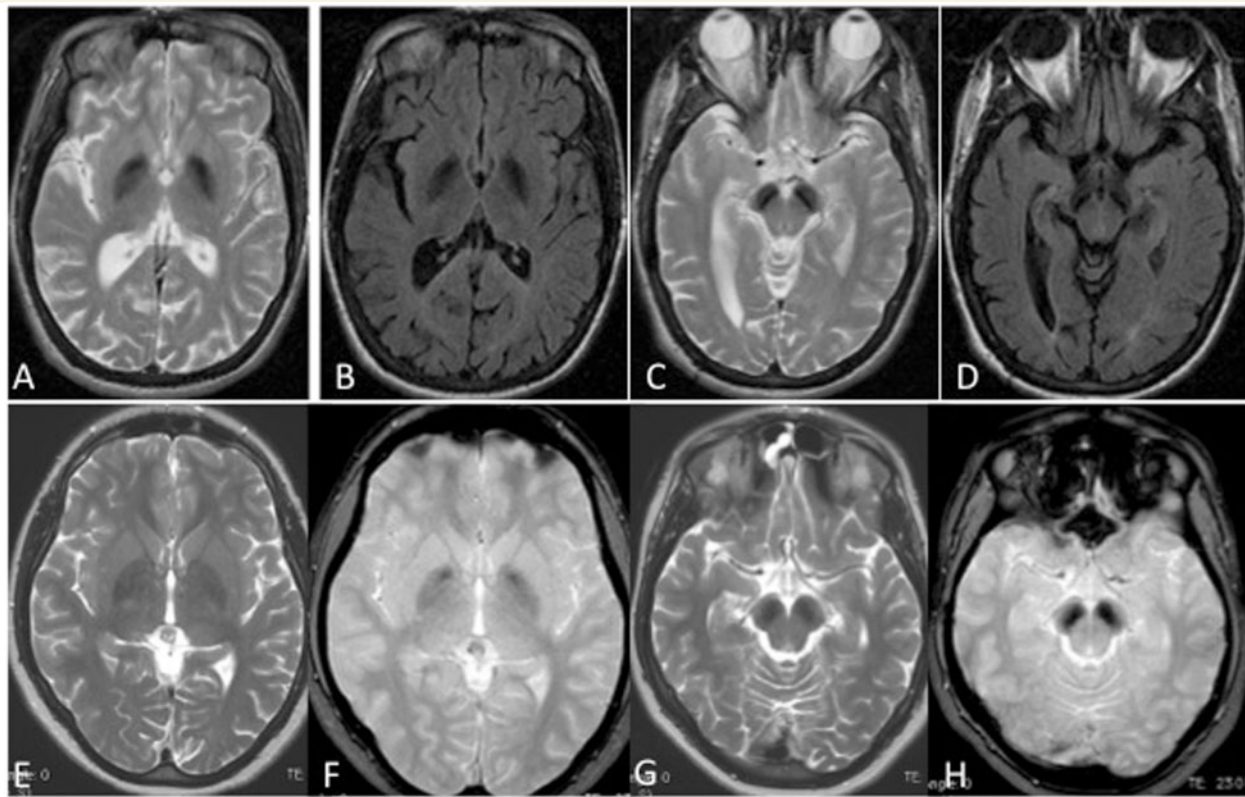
MRI showing iron in BPAN. The globus pallidus is variably hypointense on axial T₂ (A and E) and more so on FLAIR sequence (B) and T₂* sequence (F). Substantia nigra (T₂, C and G; FLAIR, D; T₂*, H) shows even greater hypointensity, indicating high levels of iron in these structures.
